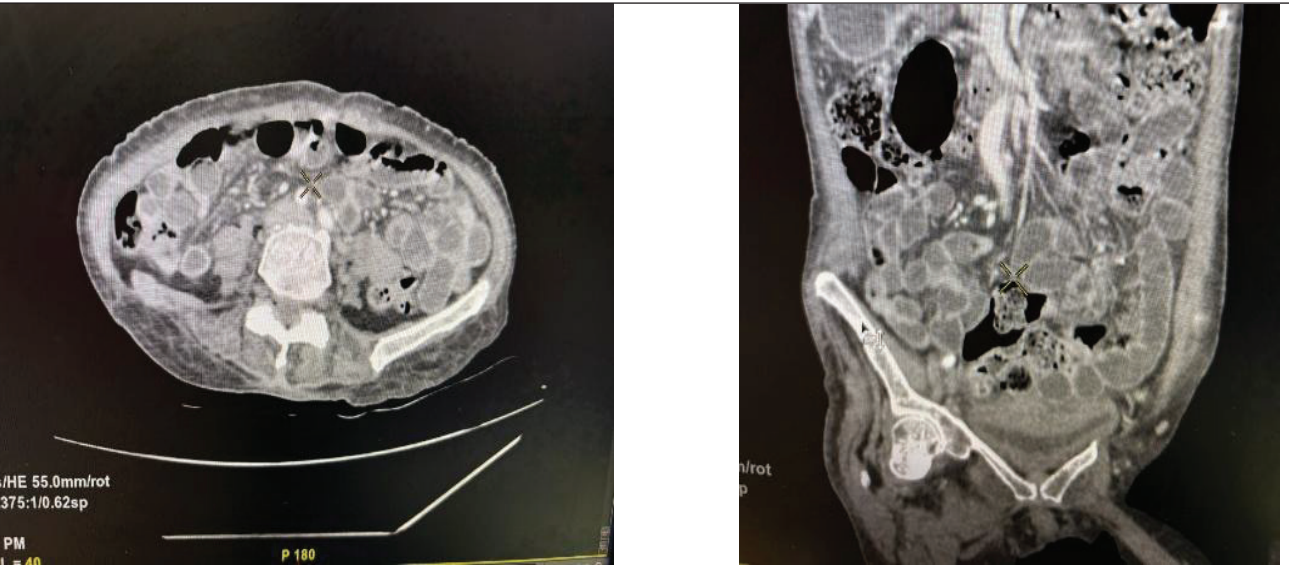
(a) Contrast CT axial abdomen axial. (b) Contrast CT sagittal abdomen.
